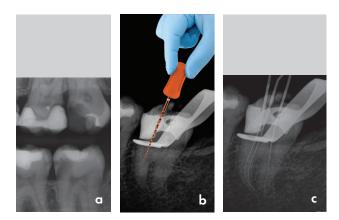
(a) Pre-operative bitewing radiograph showing the large carious lesion on the mandibular left second molar tooth; (b) ProTaper Ultimate Shaper X used to create more straight-line access into the two mesial root canal systems; (c) Length determination periapical radiograph
